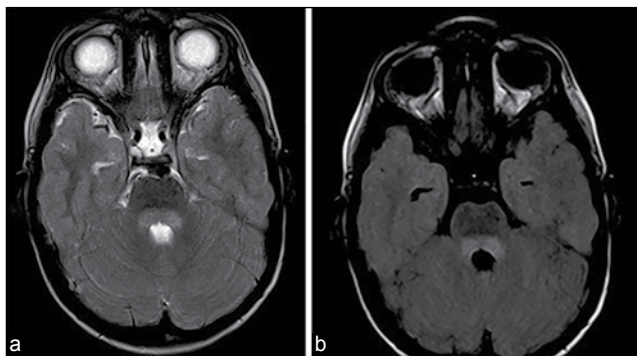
Axial T2/FLAIR MRI images reveal hyperintense lesions involving the dorsal pons (1a and b)
